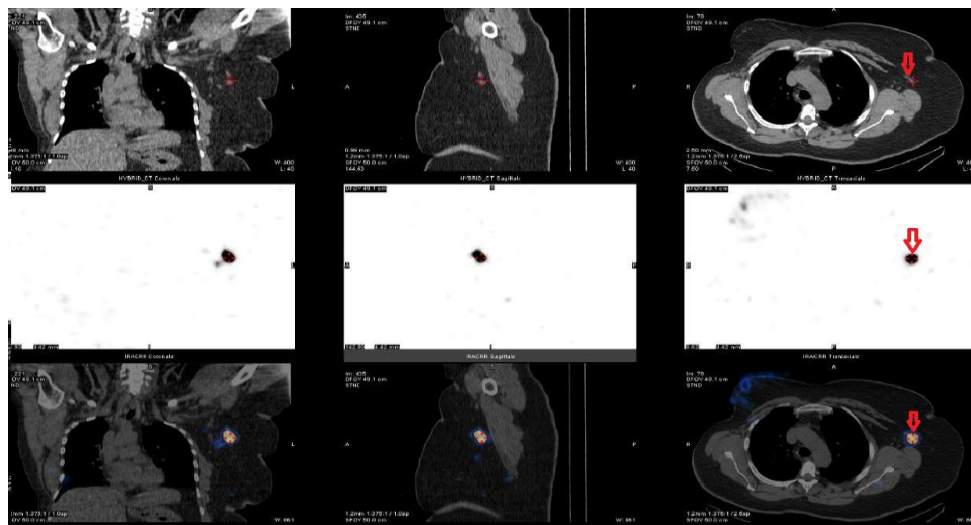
Upper, middle, and lower rows from right to left coronal, sagittal, and axial CT, SPECT, and fused SPECT/CT images, respectively, localizing the sentinel node at left axilla (level I).
